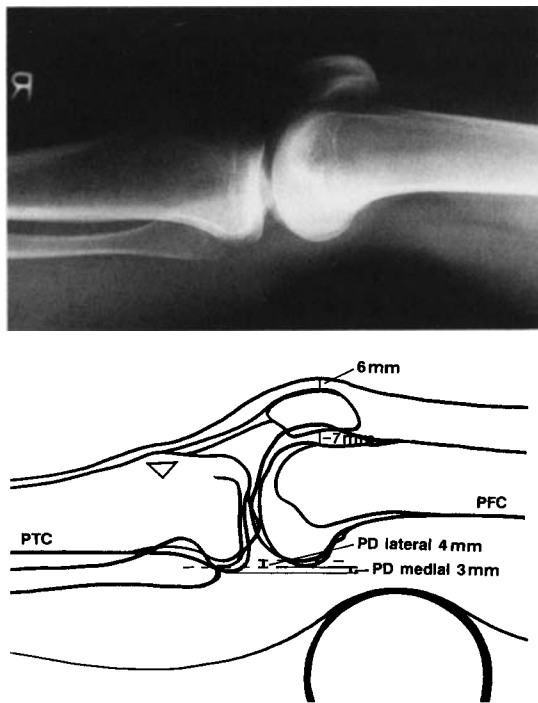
Starting position.* In the supine position, with the distal thigh supported and the quadriceps muscles relaxed (knee in 15 to 20 degrees of flexion), a minimal amount of bicompartmental posterior displacement (PD), measuring 4 mm for the lateral and 3 mm for the medial compartment, can be documented by a nonstressed unconstrained lateral radiograph in the sagittal plane. This represents gravity-induced laxity-dependent posterior joint play for that individual patient. The soft tissue anterior to the patella is 6 mm; the distance between the patella and trochlea is 7 mm. Arrowhead on the anterior tibia indicates direction of gravity.
